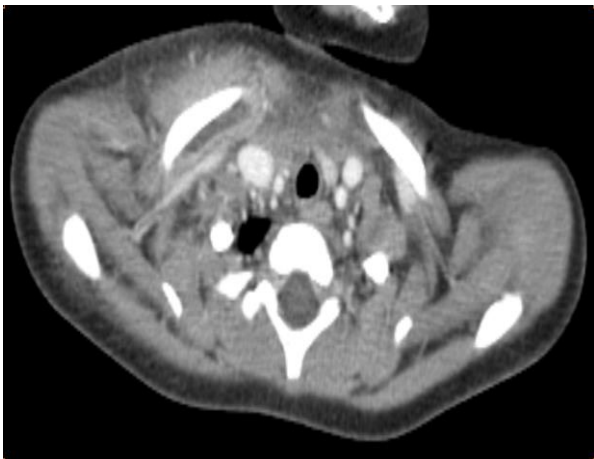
Thoracic CT scan in axial section demonstrating a hypodense juxta-osseous collection extending along the inner two-thirds and lower surfaces of the right clavicle, with hypodense contents, a thin wall enhanced after injection of contrast material, spanning approximately 40 mm, and reaching a maximum thickness of 05 mm posteriorly
